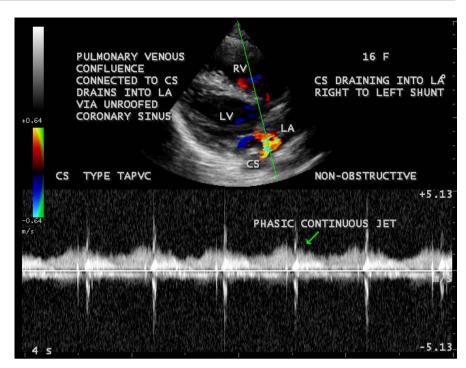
CW (Continuous Wave) Doppler showing the phasic continuous jet of pulmonary venous confluence connected to CS (coronary sinus)—non-obstructive type, draining into left atrium.
